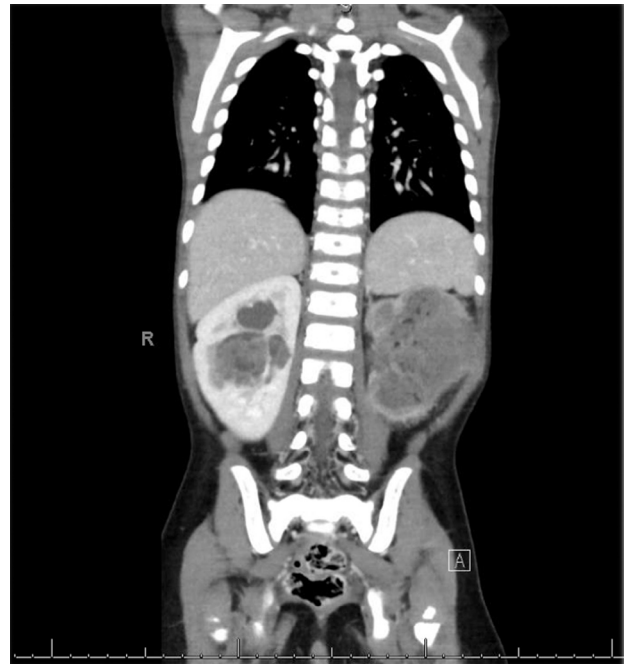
Computed tomography of the chest, abdomen, and pelvis at presentation showing a centrally located mixed-attenuation mass in the right kidney in addition to the left renal mass.
